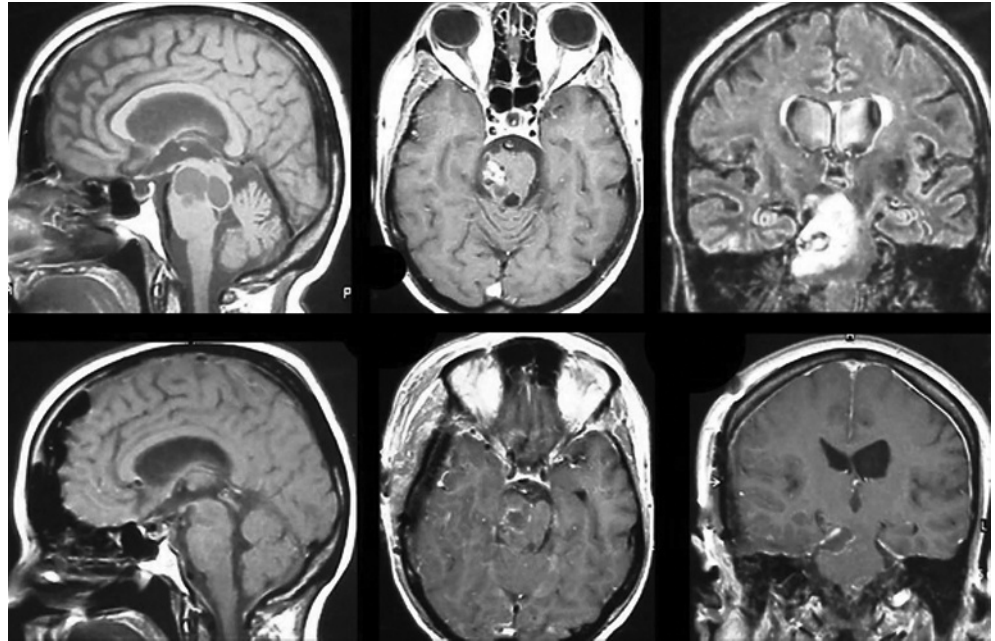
Top row, preoperative MRI from a patient mistakenly diagnosed in the past with brainstem glioma and treated with radiation therapy. Bottom row, postoperative MRI after resection of pathologically proven cavernous malformation.
